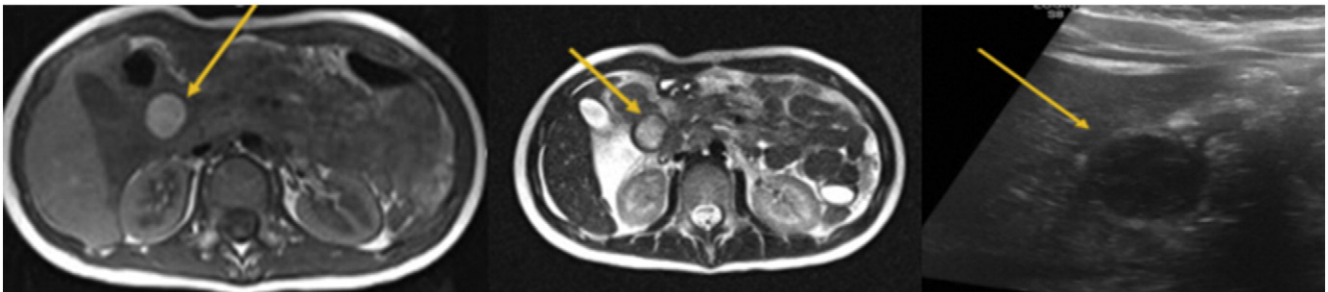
T1- and T2-weighted turbo spin-echo MR images (left and middle) of a cystic lesion near the descending duodenum. Ultrasound image (right) shows a hypoechoic cystic lesion with low-level internal echoes and a thickened wall without typical gut signature.
